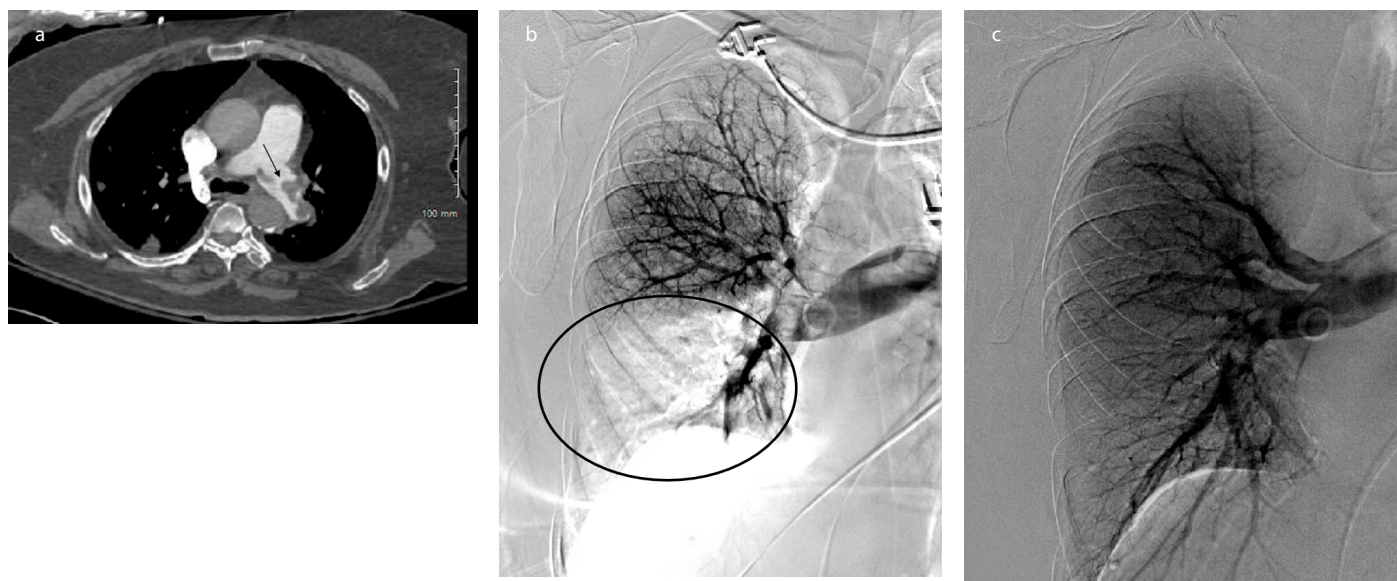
(a) Helical computed tomography scan of the pulmonary arteries, demonstrating a large clot burden within the left pulmonary artery (black arrow). (b) Pulmonary angiogram revealing a large filling defect within the right lower lobar pulmonary artery (black oval). (c) Post mechanical thrombectomy pulmonary angiogram demonstrating the complete opacification of the right lower lobar pulmonary artery.
